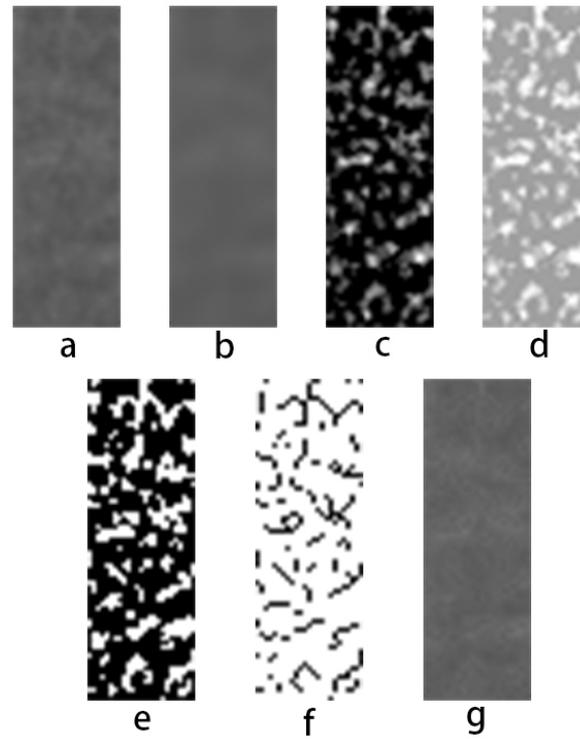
Steps of fractal analysis on panoramic radiographs. (a) Raw image before processing. (b) Gaussian blurred image. (c) Result of subtracting blurred image from raw image. (d) Grayscale offset. (e) Binarized. (f) Invert, skeletonize. (g) overlay.
